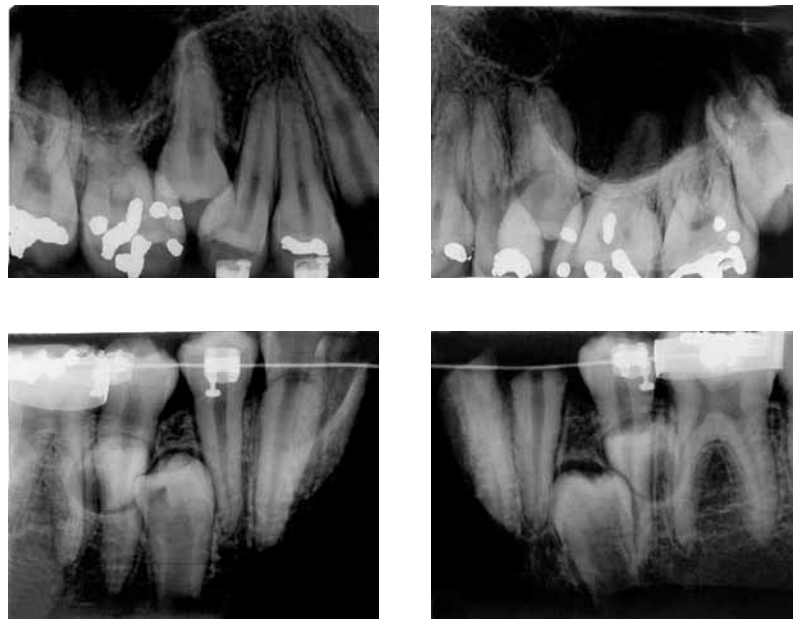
Postmortem radiographs show supernumerary teeth in maxillary and mandibular arches, as well as brackets and bands in mandibular molars.
